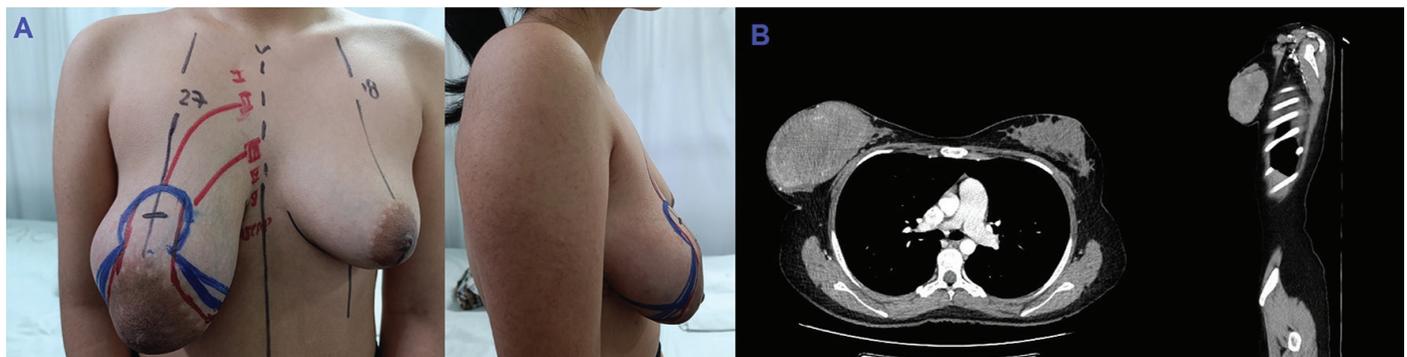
Case 2; (A) Preoperative image of the right breast showing the tumor and marked asymmetry. (B) Computed tomography image demonstrating the interface of the extensive tumor with the pectoralis major fascia
